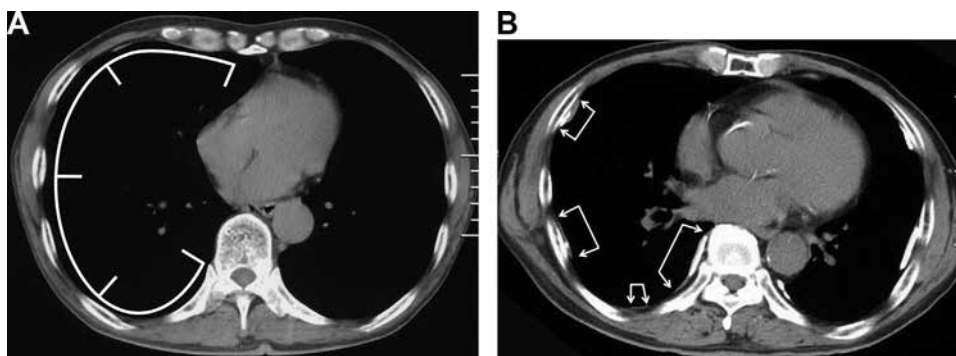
(A) Division into quarters of the inner chest wall on computed tomography (CT) image. A CT section was selected with the most extensive pleural plaque in the left or right side of the chest. The inner chest wall was divided into quarters. The extent of the inner chest wall line on the left or right side was established ventrally from the sternal border and dorsally to the origin of the ribs. If there were multiple plaques (including plaques observed in mediastinal pleura in the same section), the sum was calculated by adding the extent of each plaque. (B) Class 2 patient according to the computed tomography (CT)-based pleural plaque classification. The chest CT showed multiple pleural plaques with calcification. All CT sections were examined, and the section with the most extensive pleural plaques was selected. The total area of four pleural plaques (shown in the figure) was more than one fourth of the inner chest wall. Thus, the patient was determined to be Class 2.
